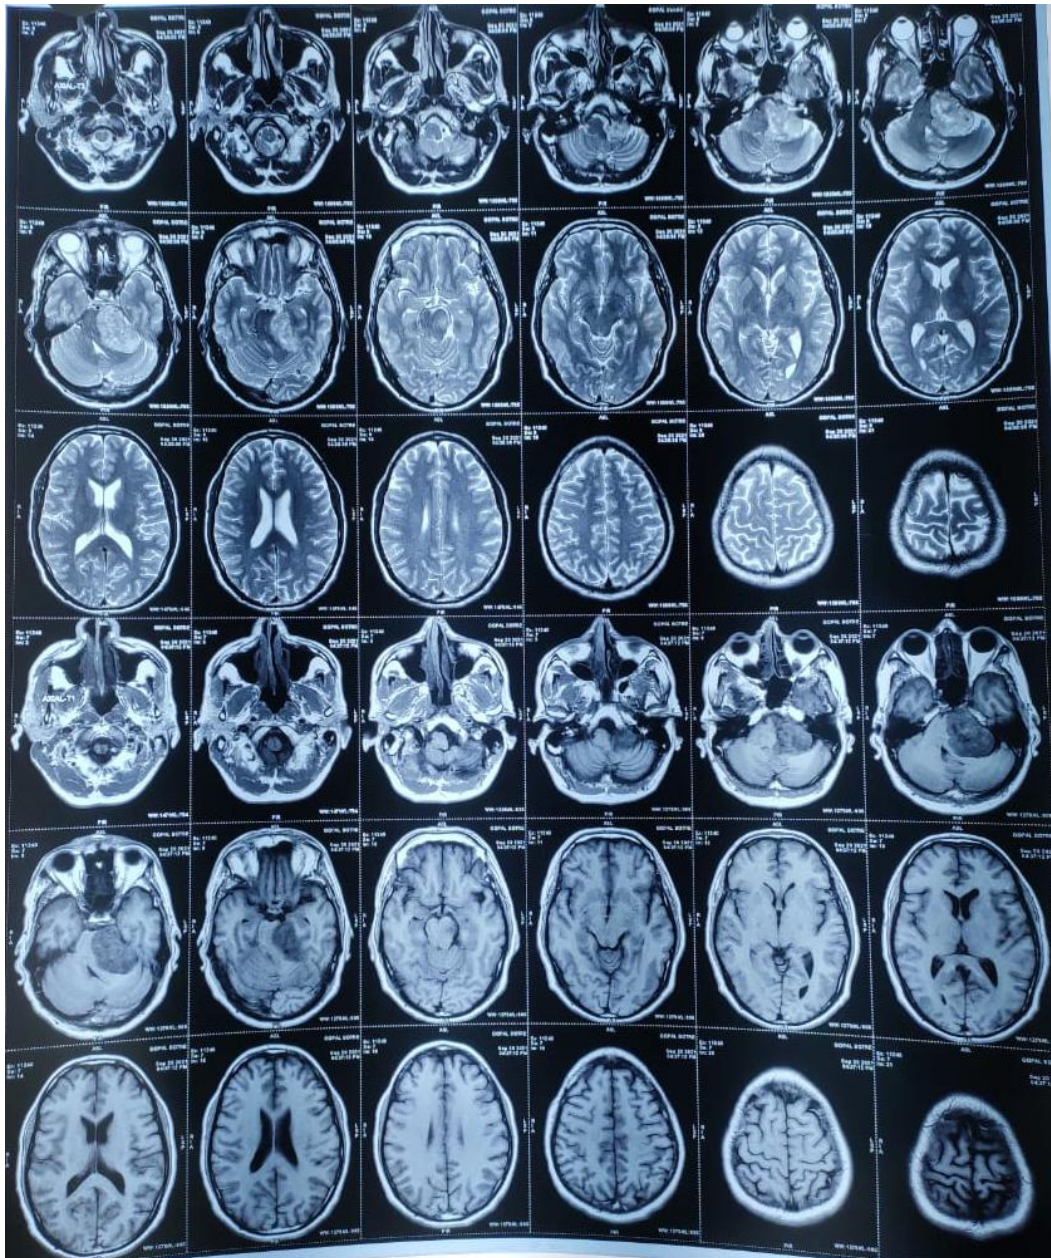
T2 image of MRI
